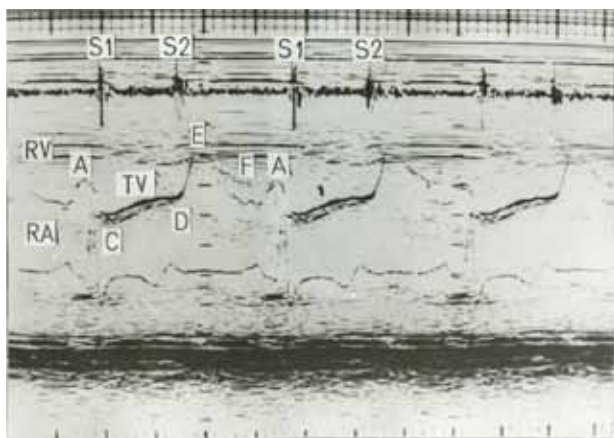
ECHOPHONOCARDIOGRAM AFTER SUCCESSFUL SURGICAL REMOVAL OF THE LARGE ASYMPTOMATIC RIGHT ATRIAL MYXOMA. PATHOLOGICAL SOUNDS DISAPEARED. Left parasternal short axis view. S1-first heart sound;S2-second heart sound;RA-right atrium;RV-right ventricle;TV-tricuspid valve
